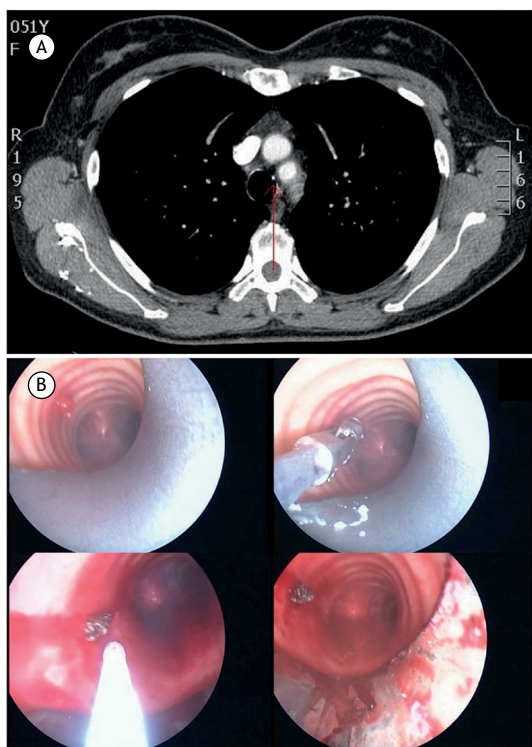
In A, a chest CT scan with contrast enhancement showing a small lesion in the left lateral wall of the trachea (red arrow). In B, bronchoscopic images confirming the presence of a purple polypoid lesion in the left lateral wall of the lower third of the trachea; removal of the lesion (with forceps) resulted in significant hemorrhage, which was controlled with laser photocoagulation.
